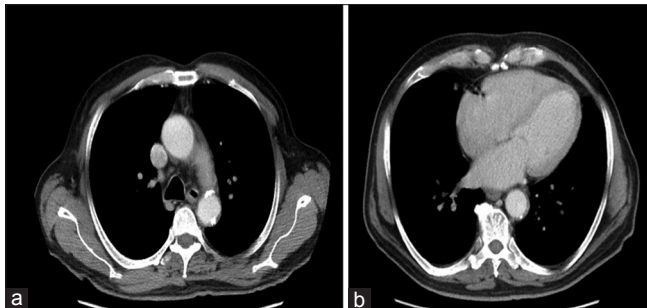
(a and b) No other distant metastasis to the liver or to the thorax by thoracic magnetic resonance imaging
